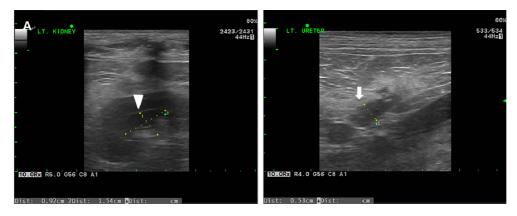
Abdominal ultrasonographs of the left kidney and proximal ureter. (A) Distension of the left renal pelvis (0.92 cm) (arrow head) was decreased. (B) Distension of the proximal ureter (0.44-0.53 cm) (arrow) was decreased.
